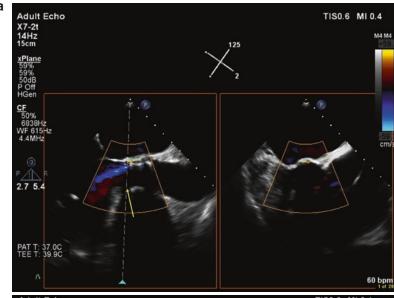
Assessment of PAR in the cath lab by TOE after valve deployment. (a) An example of mild PAR however it's important to note that the shadow at the anterior part of the valve (yellow arrow) may obscure other regurgitant jets. Gastric views could be helpful in detecting other potential PAR jets. (b) An example of severe PAR. The small jet that is visible in non coronary cusp (yellow arrow) appeared to be more significant in a different plane that is shown in (c). (d) More accurate assessment of PAR can be done by measurement of the 3D vena contracts area using multiplanar reconstruction of a zoomed 3D colour Doppler dataset
